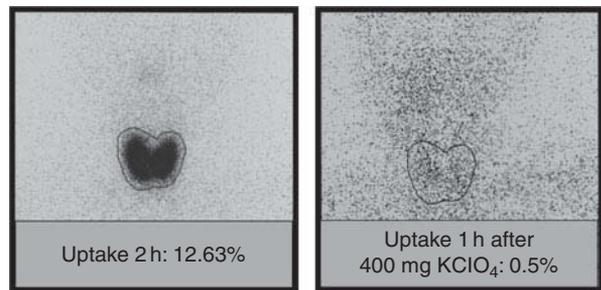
The figure shows thyroid scintigraphy with ^{123}I and a perchlorate (KClO_4) testing in a child affected with TIOD due to TPO mutations. A high radioiodine uptake (12.63%, normal values 1–5) is observed at the second hour, and a total discharge 1 h after the administration of 400 mg of KClO_4 is also documented.
